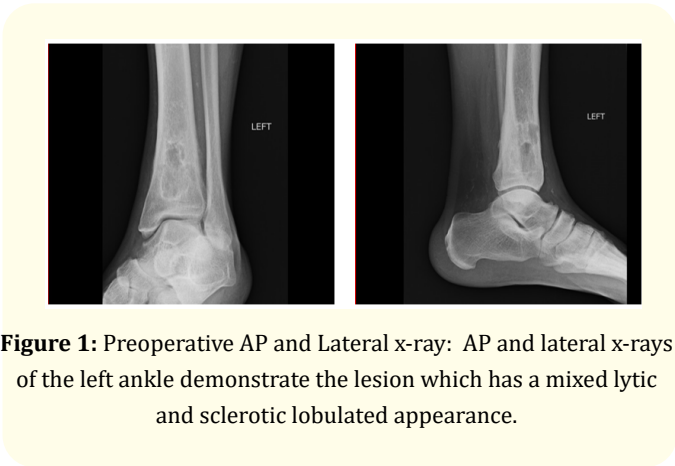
Preoperative AP and Lateral x-ray: AP and lateral x-rays of the left ankle demonstrate the lesion which has a mixed lytic and sclerotic lobulated appearance.
